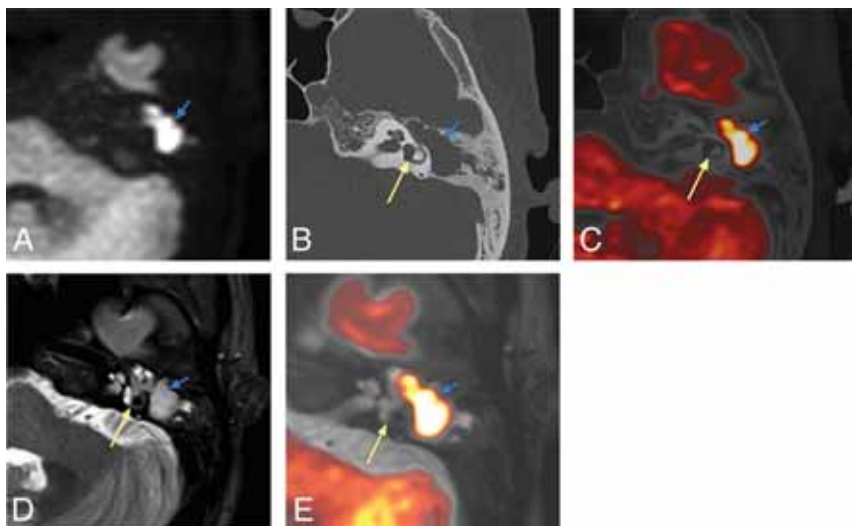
Pathologically confirmed cholesteatoma. The attic and mastoid antrum are filled with cholesteatoma during the operation. A, TSE-DWI: a high signal intensity area (blue arrow) is seen in the mastoid of the left middle ear with clear borders and poorly displayed semicircular canal. B, HRCT: a soft-tissue density shadow is seen within the middle ear mastoid cavity (blue arrow), and the anterior and posterior pedicles of the horizontal semicircular canal are clearly displayed (yellow arrow). CT-DWI fusion image (C) shows the cholesteatoma exceeding the posterior branch of the horizontal semicircular canal, involving the mastoid antrum. D, T2WI shows a non-specific high-intensity-signal shadow in the mastoid process of the left middle ear. E, T2WI-DWI: the horizontal semicircular canal is clear, the cholesteatoma shows yellow changes, and the lesion involves the attic and mastoid antrum.
